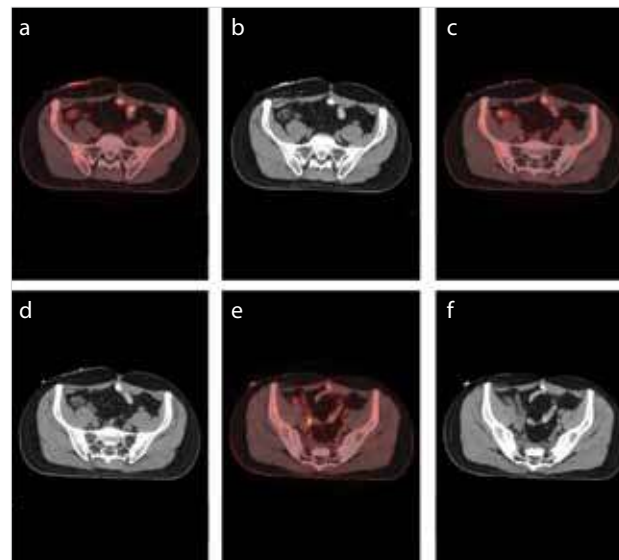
Re-staging PET/CT; 98 years-old male, rectal carcinoma. a,b,c,d) Peritoneal implants posterior to the anterior abdominal wall at the pelvic level e,f) Rectosigmoid mass, presacral 12 mm lesion at the operation field
